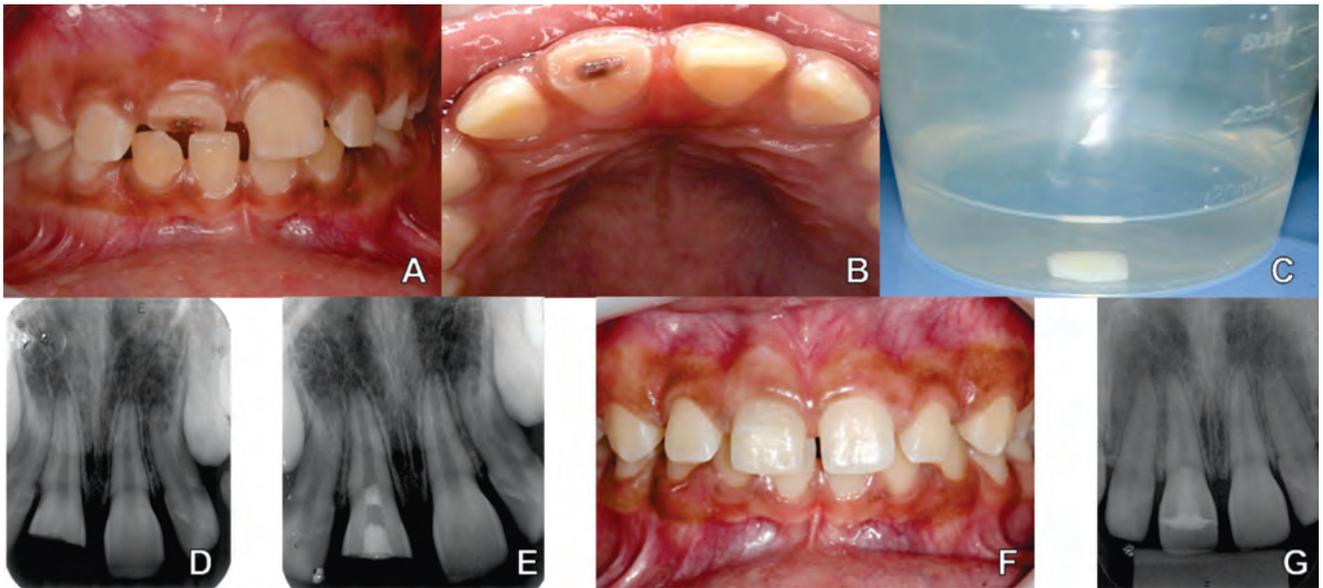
(A) Intra oral aspect of the second case; (B) Aspect of the pulp before treatment; (C) Dental fragment; (D) Initial radiographic aspect; (E) Radiographic aspect after endodontic therapy; (F) Final aspect after the reattachment of the fragment. (G) Radiographic aspect after 1-year follow-up.
